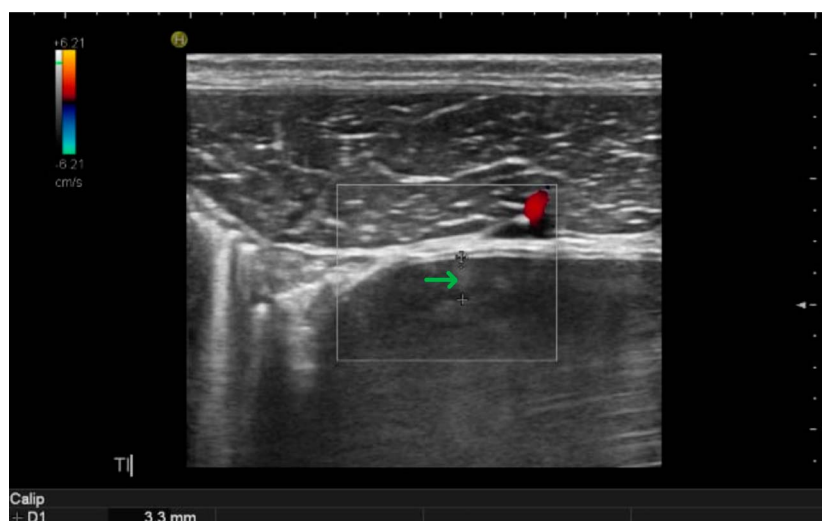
On repeat intestinal ultrasound 3 months later, wall thickness of terminal ileum was 2.8–3.1 mm (green arrow) with a modified limber vascularity score of 0/3.
